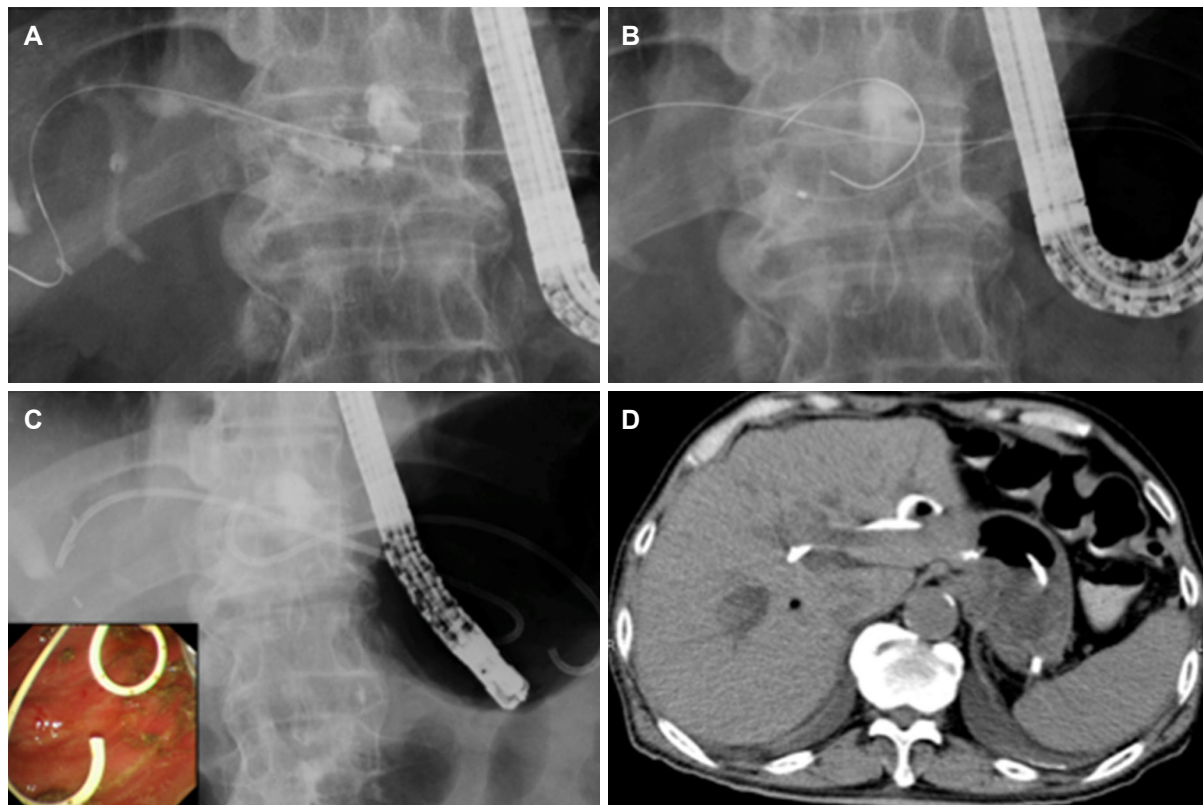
(A) Contrast-enhanced cholangioscopy image shows infected biloma; (B) guidewire placed in liver abscess and biliary tract; (C) deployed double stent; (D) computed tomography image after this procedure
